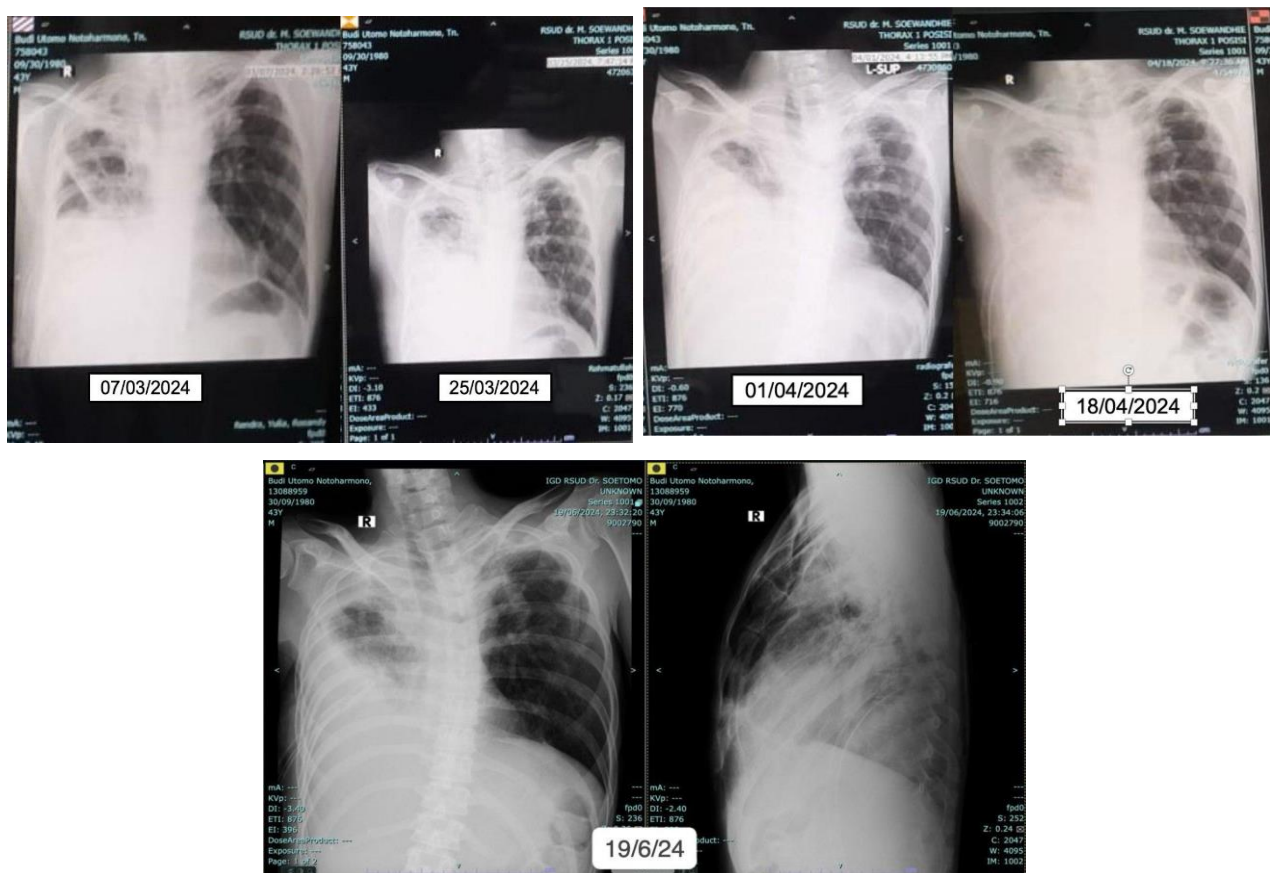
X-ray of Mr. BU's lungs.
